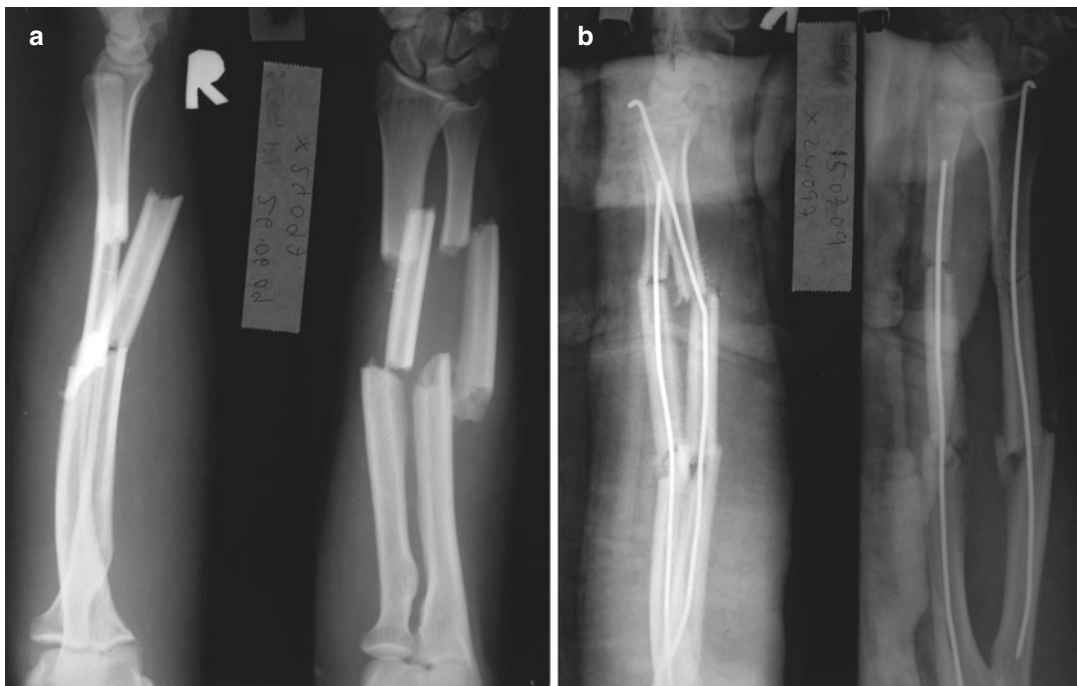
(a) X-rays of a segmental both-bone forearm fracture. (b) Repaired with thin Rush rods opening the fracture site
